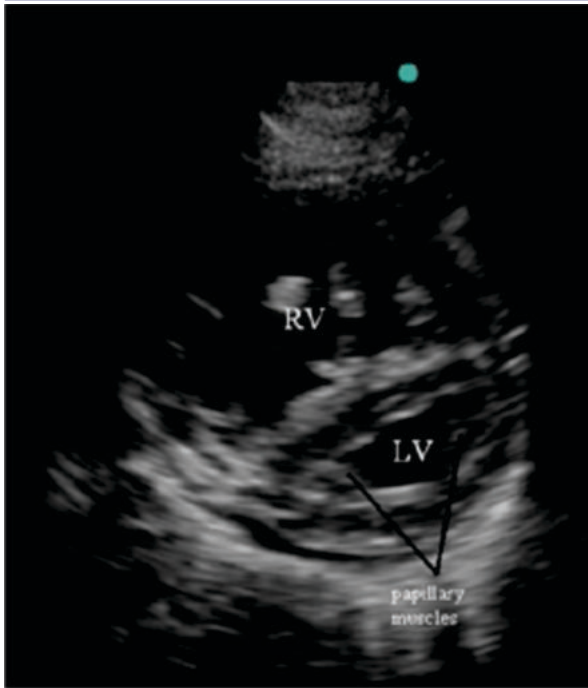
Echocardiographic Sign Of Rv Strain In The Parasternal Short View. Note The Characteristic D- Shaped Of The Left Ventricle(LV) In Cross Section
